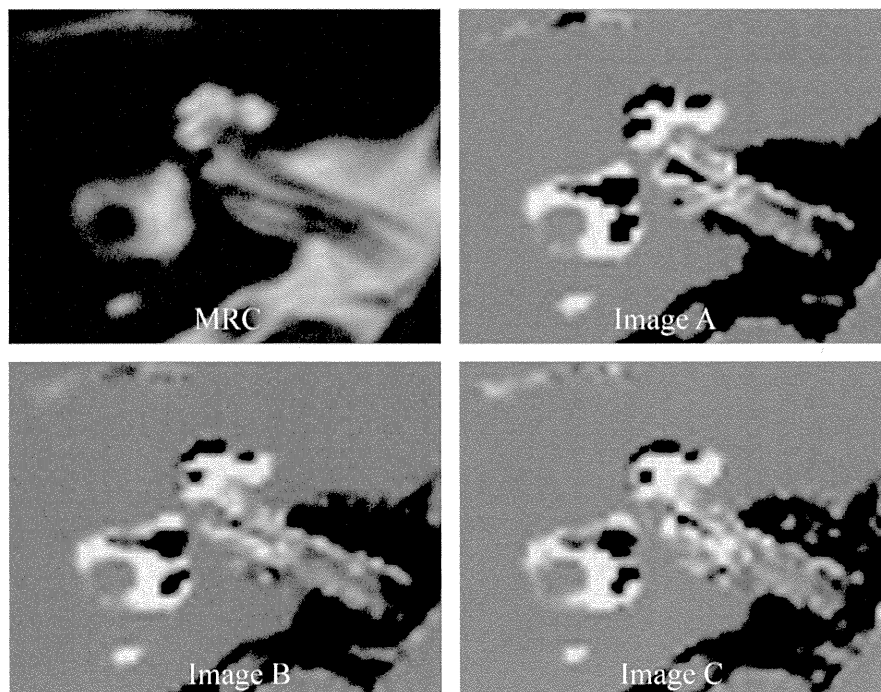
Representative images from a 50-year-old man with right fluctuating hearing loss without vertigo. Magnetic resonance cisternography (MRC) demonstrates the total space of lymphatic fluid as a bright signal. Image A is a HYDROPS-Mi2 image (HYbrid of Reversed image Of Positive endolymph signal and native image of positive perilymph Signal-Multiplied by T_2) generated from 3 kinds of image data and obtained in a total scan time of 31 min. Images B and C are HYDROPS2-Mi2 images (HYbrid of Reversed image Of MR cisternography and a positive Perilymph Signal by heavily T_2 -weighted 3D-FLAIR-Multiplied by T_2). Image B is generated from 2 kinds of image data obtained with a total scan time of 17 min, whereas Image C is generated from 2 kinds of image data obtained with a total scan time of 10 min. In Images A, B, and C, the black areas in the cochlea and vestibule are estimated as endolymph, and the white areas are estimated as perilymph. In this particular ear, significant endolymphatic hydrops is seen in the cochlea but not in the vestibule in all Images A, B, and C.
